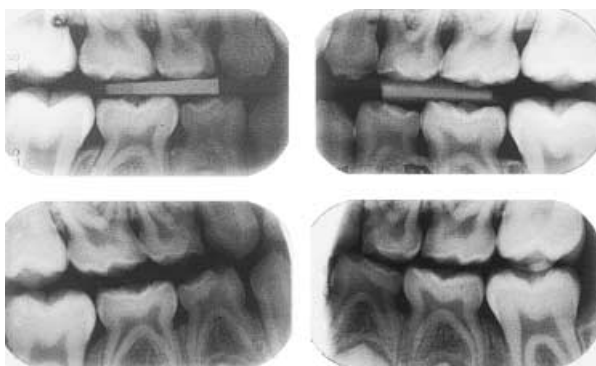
Bitewing radiographs of the dizygote twins (7-year-old) with localized aggressive periodontitis. Marginal bone loss was visible in one of the twins (upper two radiographs) at the teeth 54, 63 and 64, and on the other twin (lower two radiographs) at the teeth 64 and 65, where the distance between the cementum-enamel junction and the marginal bone level was 3 mm on one of the proximal surfaces.
